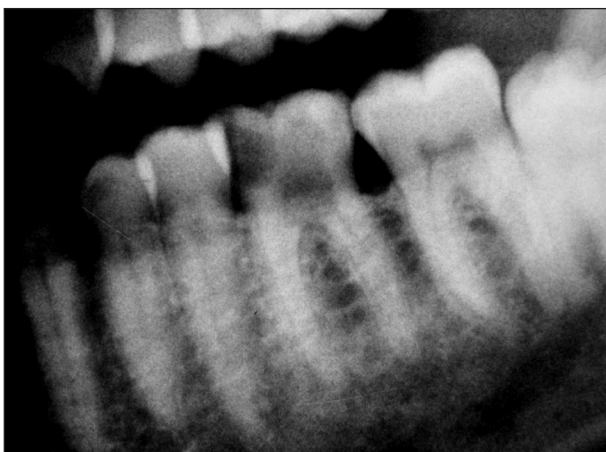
Radiograph shows the presence of a perforation in the floor of the pulp chamber in the furcation area of tooth 36.
